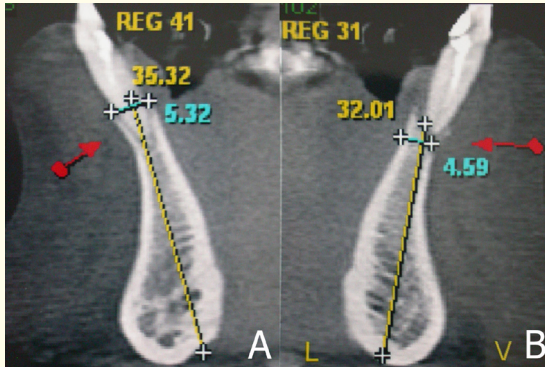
Remaining bone on teeth 31 and 41 (computed tomography - cross sections).
